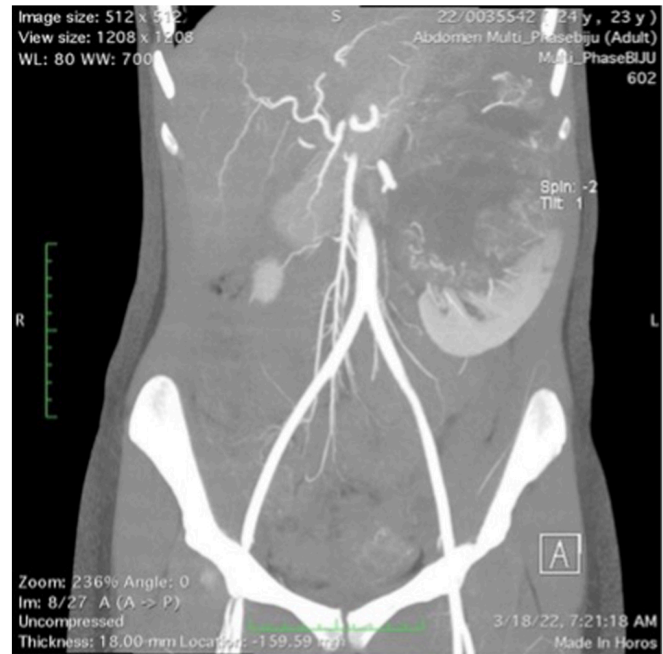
Abdomino-pelvic computed tomography scan showing left Wilms tumor (coronal view).
